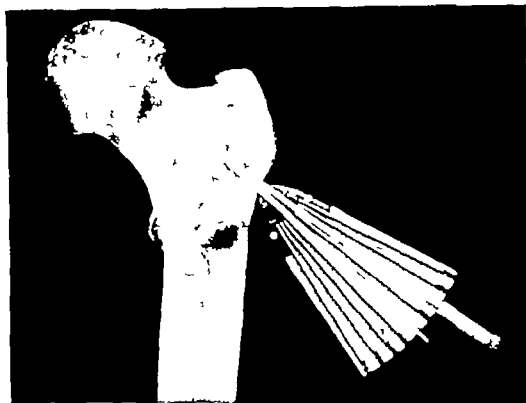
From anteroposterior x-ray picture, converging line, which is in long axis of neck of femur is selected. Second pin is inserted through corresponding canal in opposite row of canals to which first pin was inserted. (G. C. Engel and H. May: J. A. M. A.)
